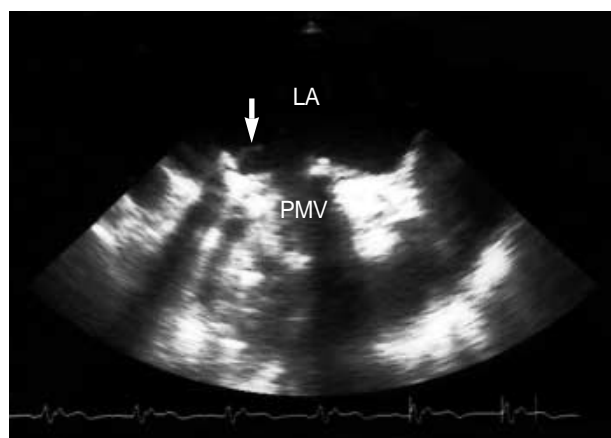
Transesophageal echocardiogram showed a thread like structure attached to the rim of the prosthetic mitral valve. PMV: Prosthetic mitral valve, LA: Left atrium.
